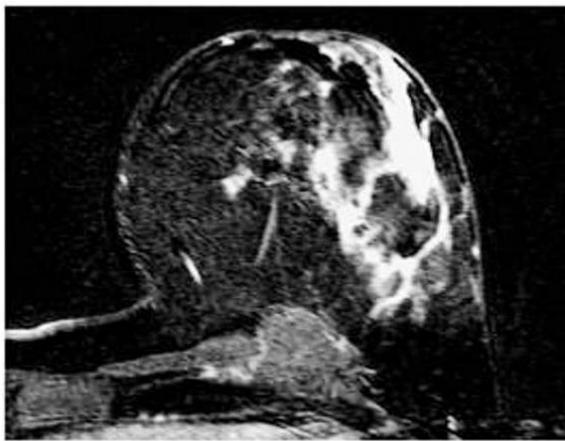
Breast MRI. Contrast medium spreads and accumulates mainly in neoangiogenetic foci. Thanks to this feature, a more precise assessment of DCIS extension is possible.
